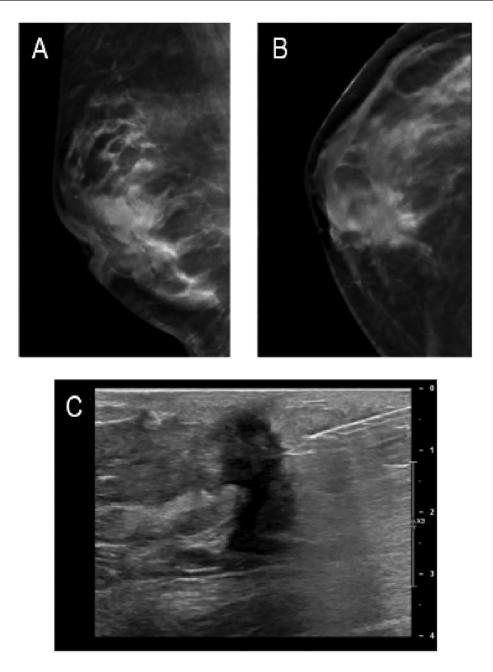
(A and B) MLO and CC digital breast tomosynthesis and (C) Core biopsy pre-fire ultrasound of the retroareolar mass.
